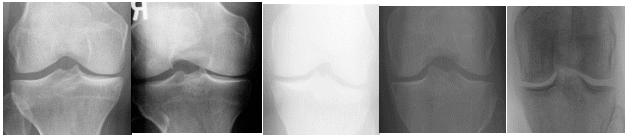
Similar Knee X-ray images corresponding to Grade 1 (Doubtful).
